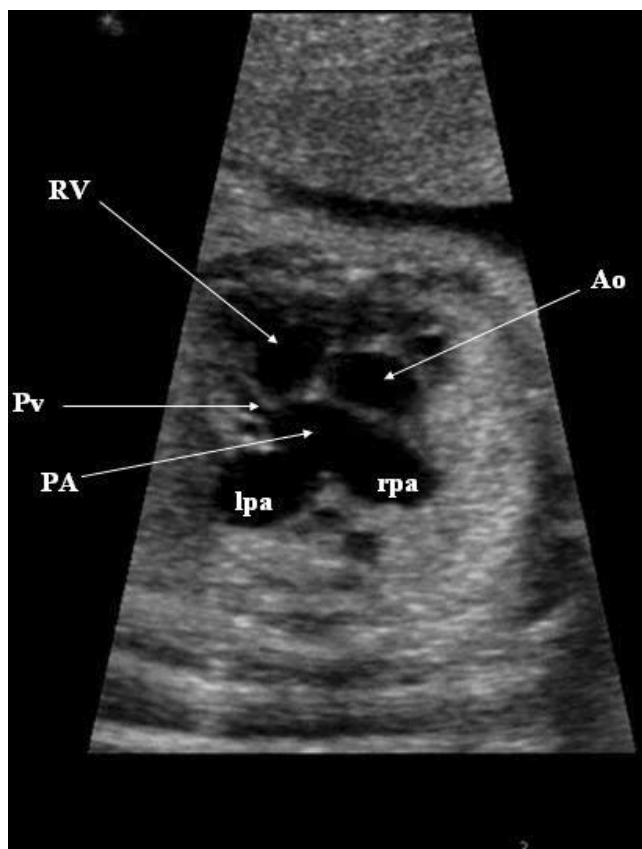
Typical echocardiographic image in the second half of pregnancy of a fetus with absent pulmonary valve displaying the marked dilatation of the central pulmonary arteries. Ao, ascending aorta; lpa, left pulmonary artery; PA, pulmonary artery; Pv, pulmonary valve; rpa, right pulmonary artery; RV, right ventricle.
